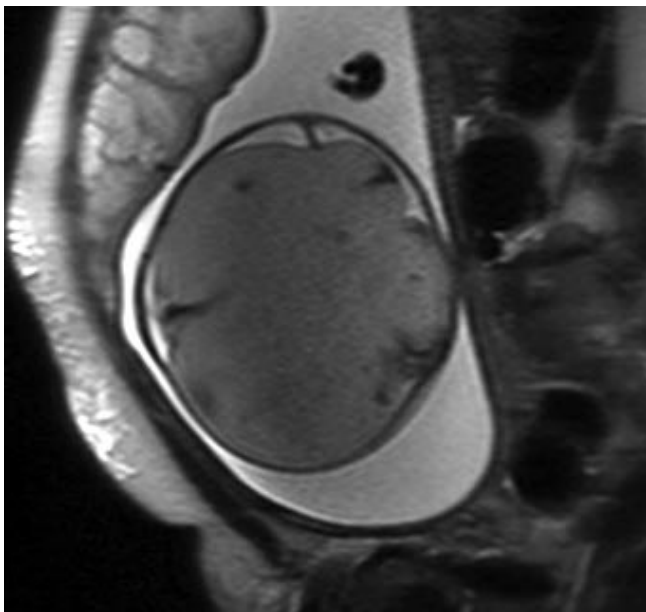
Prenatal MRI demonstrating mass occupying almost the entire cranium.
